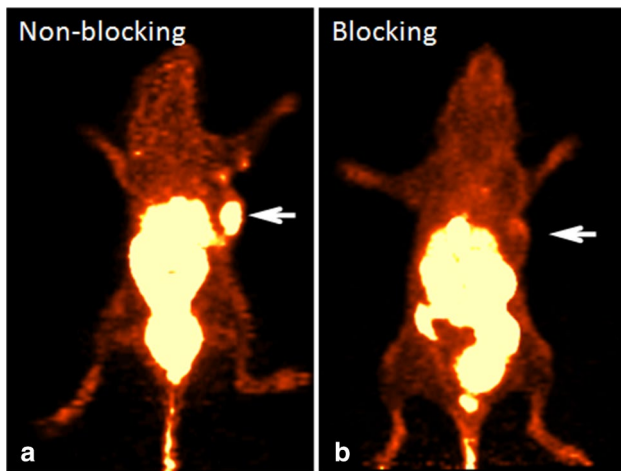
In vivo detection of HepG2 tumors using ^{18}F -AIF-NODA-MP-6-Aoc-L5 microPET/CT with and without blocking. a In vivo microPET MIP images of the HepG2 tumor models at 60 min. The tumor (arrow) was visualized clearly. b The uptake of ^{18}F -AIF-NODA-MP-6-L5 in HepG2 tumors was low, and the tumor (arrow) was invisible using PET after inhibition with an excessive quantity of non-conjugated L5 peptide
